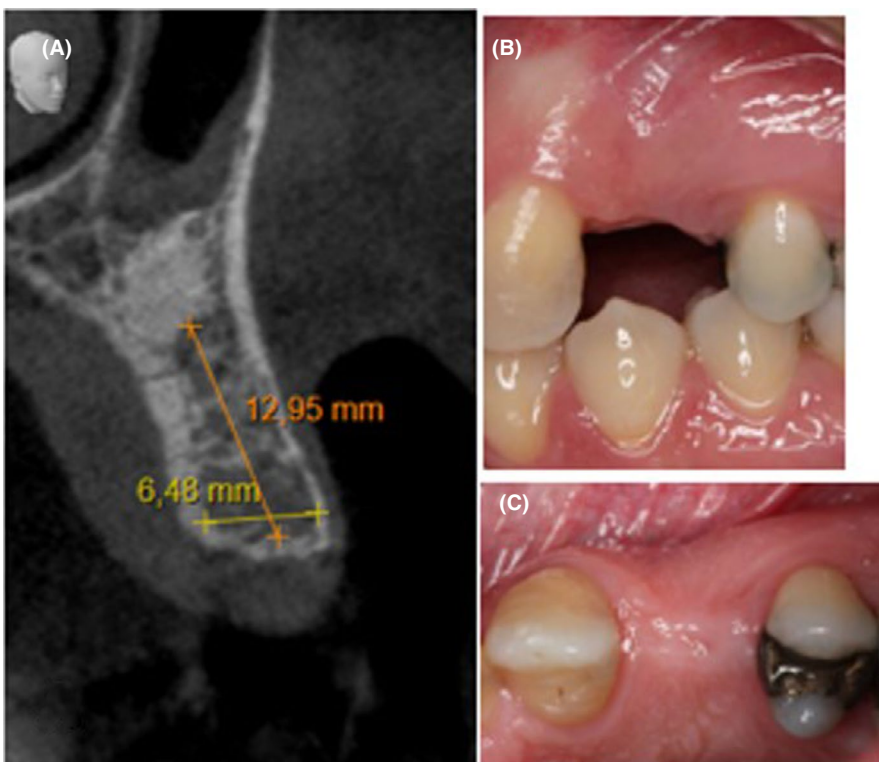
(A–C) Patient 2 pretreatment conditions. CBCT (A), lateral (B), and (C) occlusal photographs of region 24
